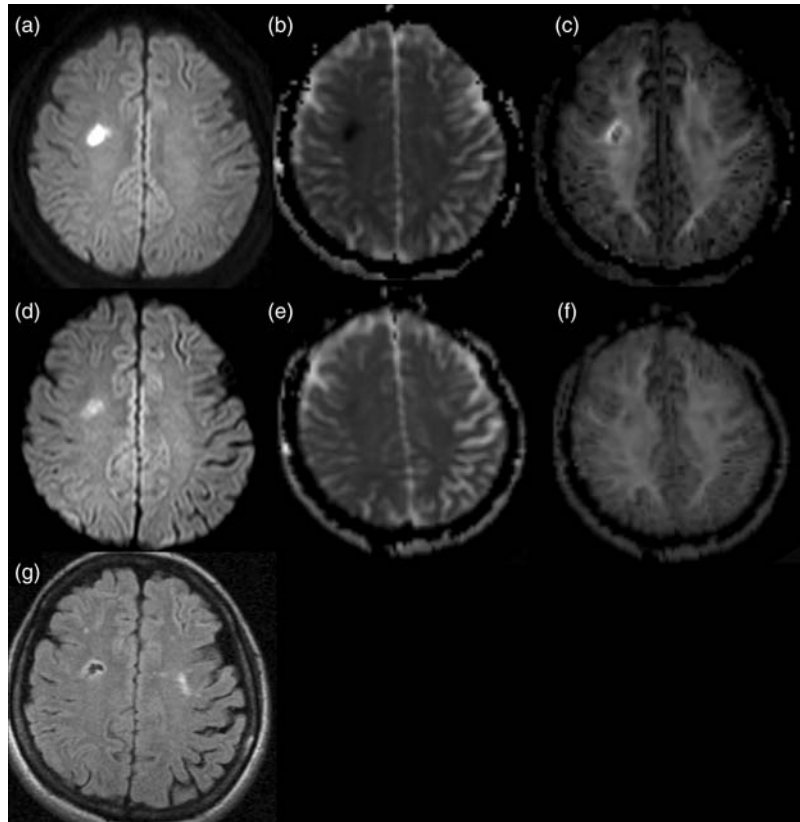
MR imaging studies of the patient. Brain MRI demonstrated multiple cerebral infarctions, including a subacute lesion in the right frontal deep white matter, which appeared as a high signal on DWI and a low signal on the calculated ADC map (a, b). However, the corresponding mean DK image shows the peripherally high intensity and dark dot in the stroke lesion (c). The mean DK values for high intensity and dark dot are 1.596 and 0.591, respectively. Two weeks later, repeated MR scanning revealed a homogenous high signal on both DWI and the ADC map (d, e) and partially normalized mean DK (f) in the corresponding ischemic lesion. The mean DK value for the normalized area is 0.842. In the FLAIR image taken 6 months later (g), the stroke lesion revealed a low signal in the central cystic portion, with peripheral high intensity, as in the first DK image
